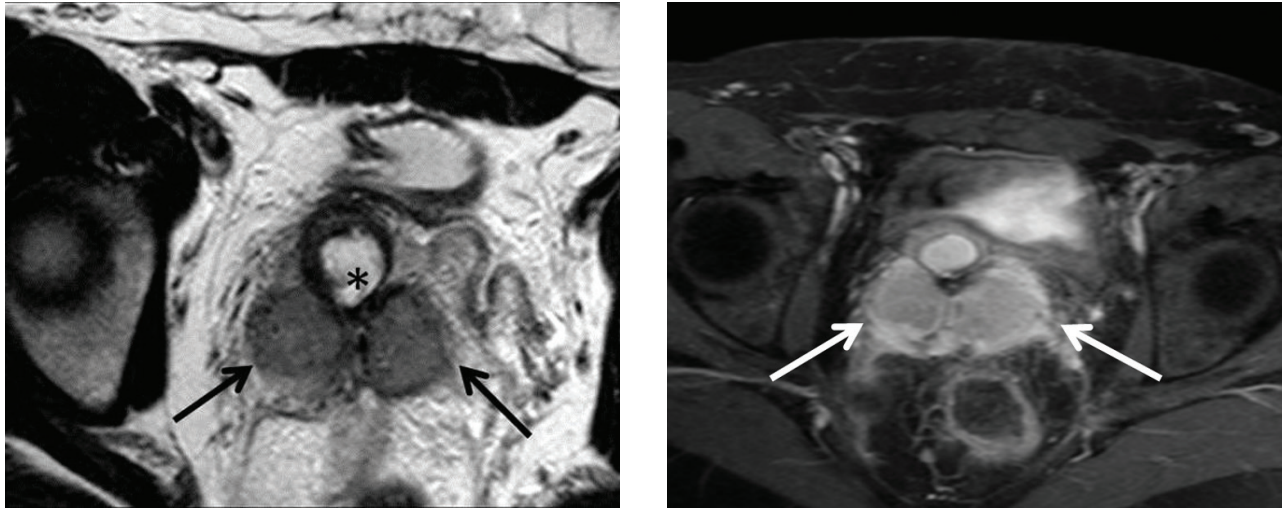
(a) Axial T2W MR image (TR/TE: 3500/90) of a 31-year-old patient, 6 months after ART. There is a soft-tissue mass (arrows) abutting the uterovaginal anastomosis (asterisk) (b) Corresponding axial T1 fat-suppressed contrast-enhanced image (TR/TE: 400/20), shows strong enhancement of the mass (arrows). Biopsy was positive for tumour recurrence
